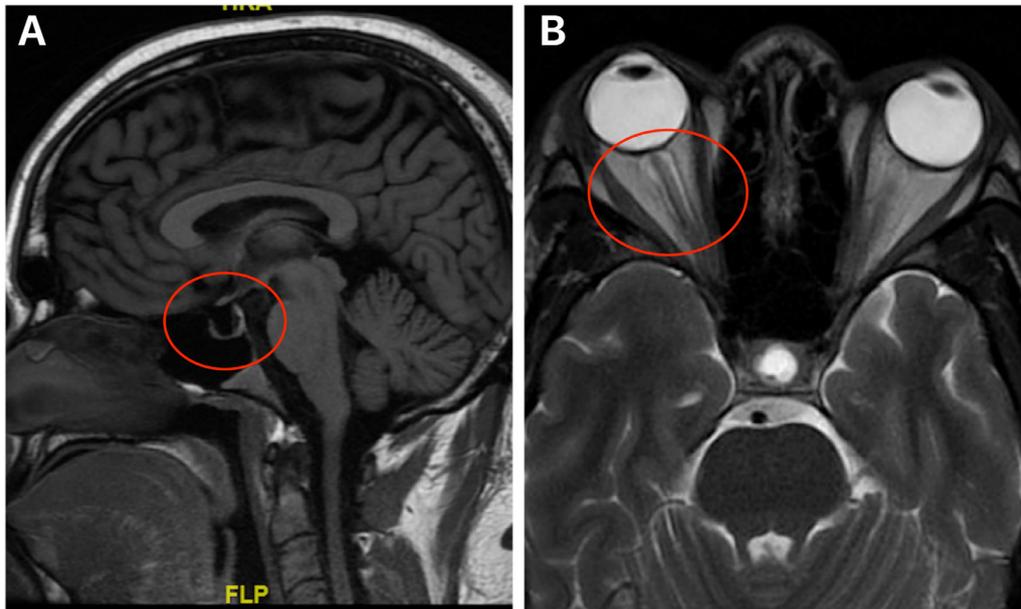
Sagittal T1 (A) and axial T2 (B) magnetic resonance images of the brain and orbit demonstrating empty sella and fluid in the optic nerve sheath, respectively.
